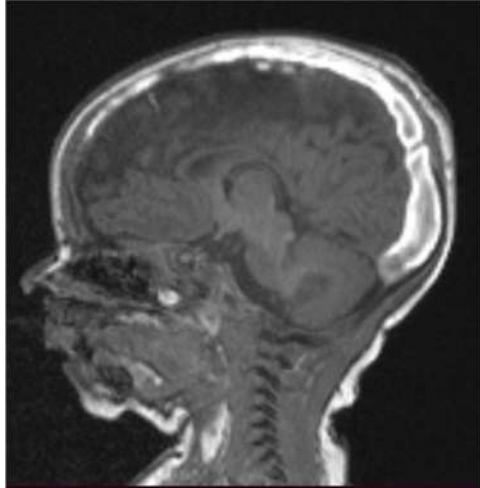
MRI Brain (Coronal section): Prominent Superior Sagittal Sinus
